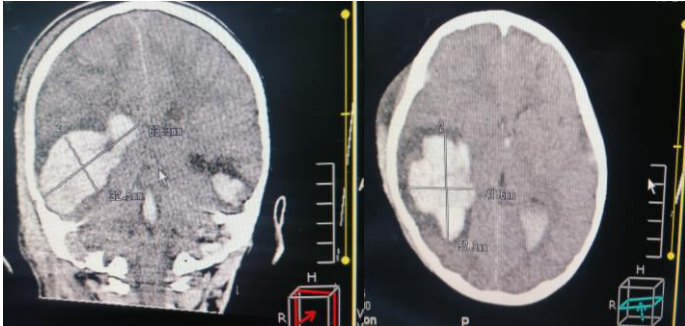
Initial CT images: pre-operative CT, brain window, axial view and coronal view showing Rt parietotemporal intracerebral hematoma and associated intraventricular hemorrhage.
